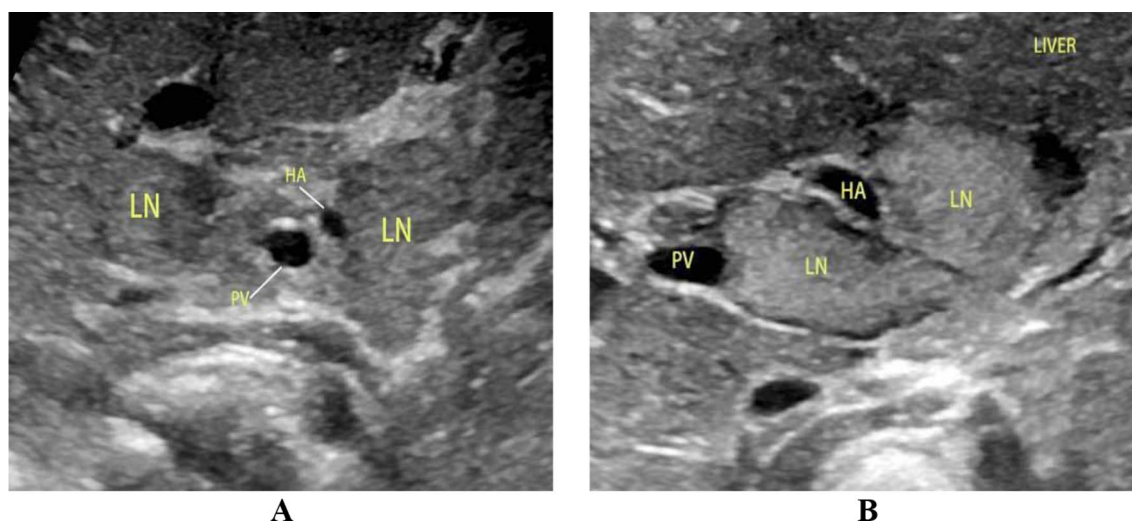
Ultrasonographic features of PHLNs in BA. (A) Male, 45 days: there were two PHLNs around the main portal vein in the hilar area, showing moderate and low echogenicity. (B) Male, 35 days: there were two PHLNs around the main portal vein in the hilar area, and echogenicity was obviously enhanced. PHLN, porta hepatis lymph node; BA, biliary atresia
